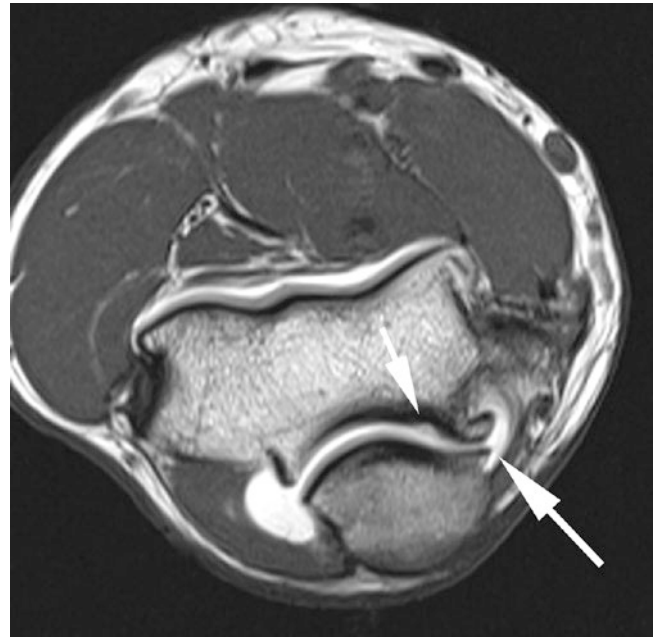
Valgus overload syndrome: posteromedial joint. Axial T1-weighted image (MR arthrogram) demonstrates prominent osteophytes along the posteromedial joint (large arrow) as well as a small focus of cartilage loss along the posterior trochlea (small arrow). Used by permission of Springer Nature
